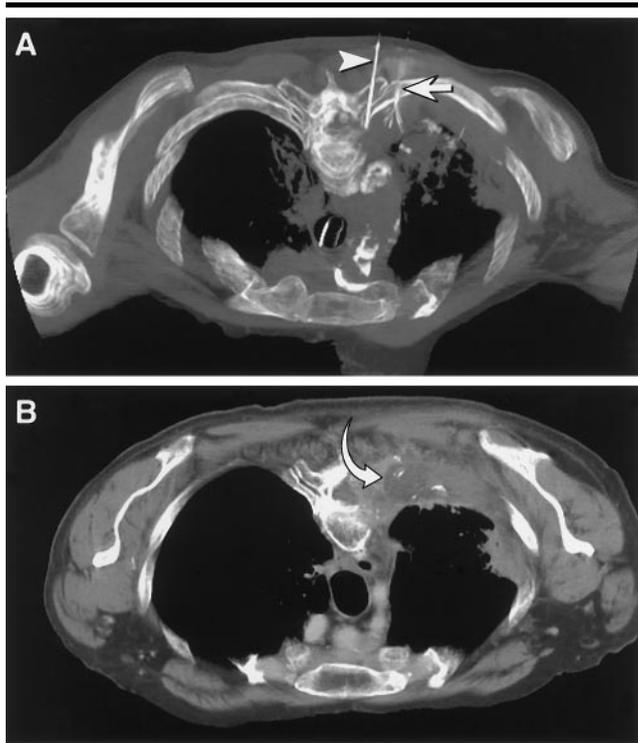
Patient 9. Transverse CT images obtained with the patient prone. *A*, Three-dimensional volume unenhanced image shows RF electrode (arrow) placed into a colorectal carcinoma metastatic lesion involving a vertebral body, rib, and adjacent pleural surface, with a thermocouple (arrowhead) placed in the region of the lateral margin of a largely destroyed left pedicle. *B*, Contrast-enhanced image of the same region, obtained 1 week after RF ablation, demonstrates a low-attenuating area (arrow), consistent with necrosis, in the paravertebral soft tissues, corresponding to the ablated region. Before ablation, the average pain score was 9. At 4, 6, and 8 weeks after ablation, the average pain score was 3, 4, and 3, respectively. At latest follow-up (16 weeks after ablation), the reported average pain score was 0.
